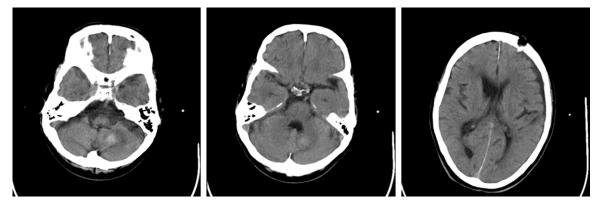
Post operative CT scan. Post operative CT scan of the patient depicted in it. Scan done seven days after surgery showing resolving hydrocephalus and the absence of intraventricular blood and posterior fossa hemorrhage.
